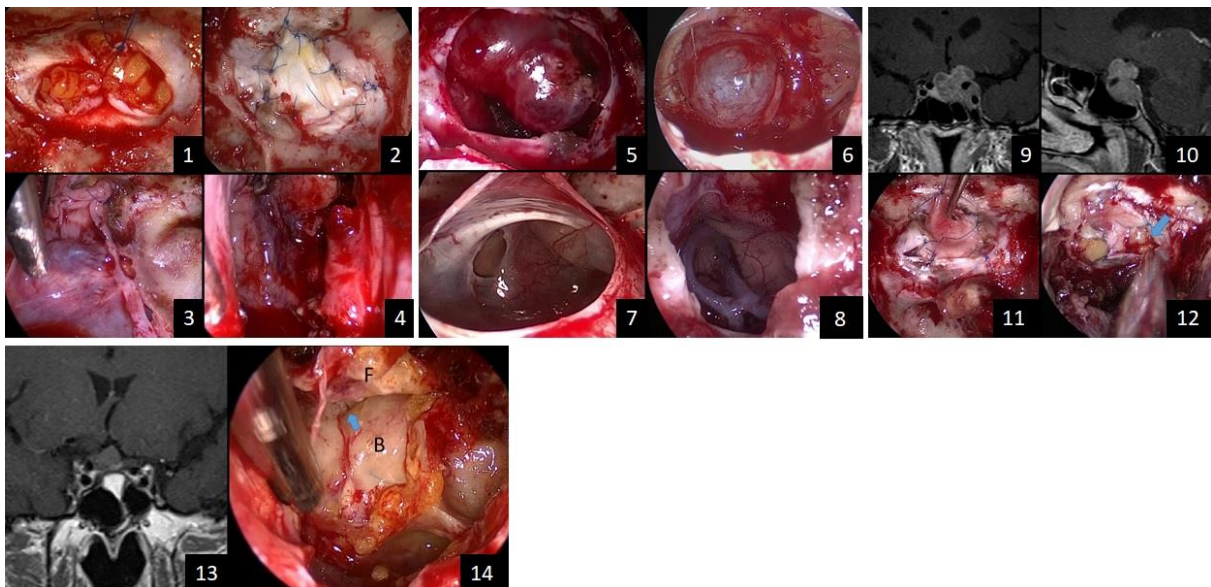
Intraoperative photograph showing skull base reconstruction in endoscopic endonasal surgery. The fat graft was packed into the cavity with anchoring dural sutures (1). Watertight duraplasty was achieved using the fascia patchwork closure technique (2). The mucosal flap from the posterior wall of the sphenoid sinus covered the sellar turcia (3). A pedicled nasoseptal flap was rotated to resurface the skull base defect at the end of the surgical procedure (4). Intraoperative photograph showing degree of CSF leakage. No leak was observed (5). Small leak was observed without obvious diaphragmatic defect (6). Moderate leak with small arachnoid defect was observed (7). High flow CSF leak was observed with large diaphragmatic and dural defect (8). Preoperative MRI showing an invasive pituitary tumor with optic chiasm compression (9,10). Intraoperative photograph showing duraplasty with fascia patchwork closure technique (11). Intraoperative photograph in repeat surgery showing leakage point (arrow) following peeling off the adhered NSF (12). Preoperative MRI showing a suprasellar tumor with optic chiasm compression (13). (14) Intraoperative photograph showing
